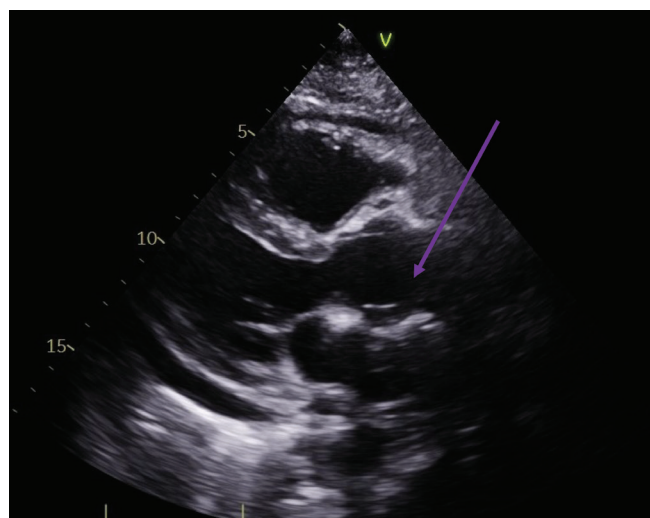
Echocardiographic image of the ascending aorta (purple arrow) after the „Florida sleeve” procedure.
